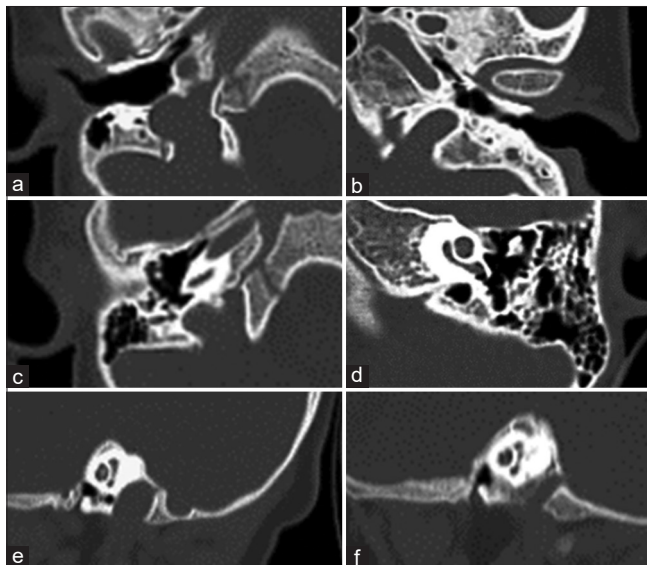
Right high riding and dehiscent jugular bulb (JB). Case 2: High-resolution computed tomography B/L temporal bone of 30-year-old female. (a) Axial section: Right dehiscent jugular bulb (b) Axial section: Left normal jugular bulb (c) Axial section: Right JB above the level of cochlea (d) Axial section: Left JB below the level of the cochlea (e) Sagittal: Right JB above the level of basal turn of cochlea (f) Sagittal: Left JB below the level of the basal turn of the cochlea
